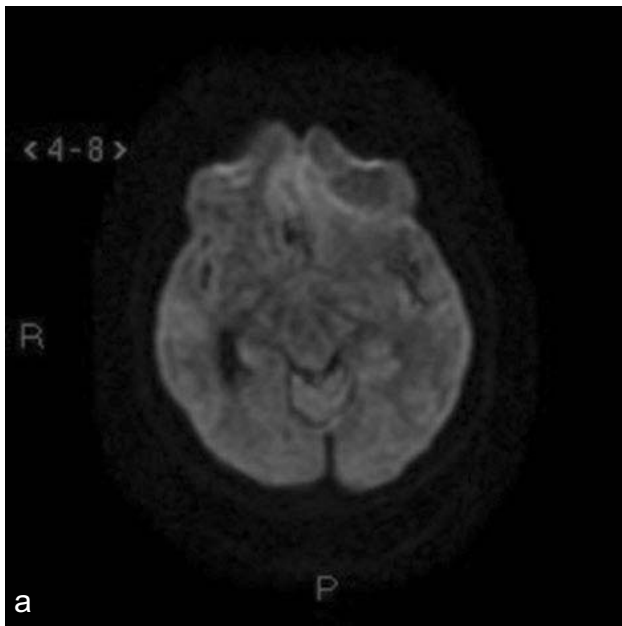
DWI and ADC map image shows no restriction in left frontal region lesion.
